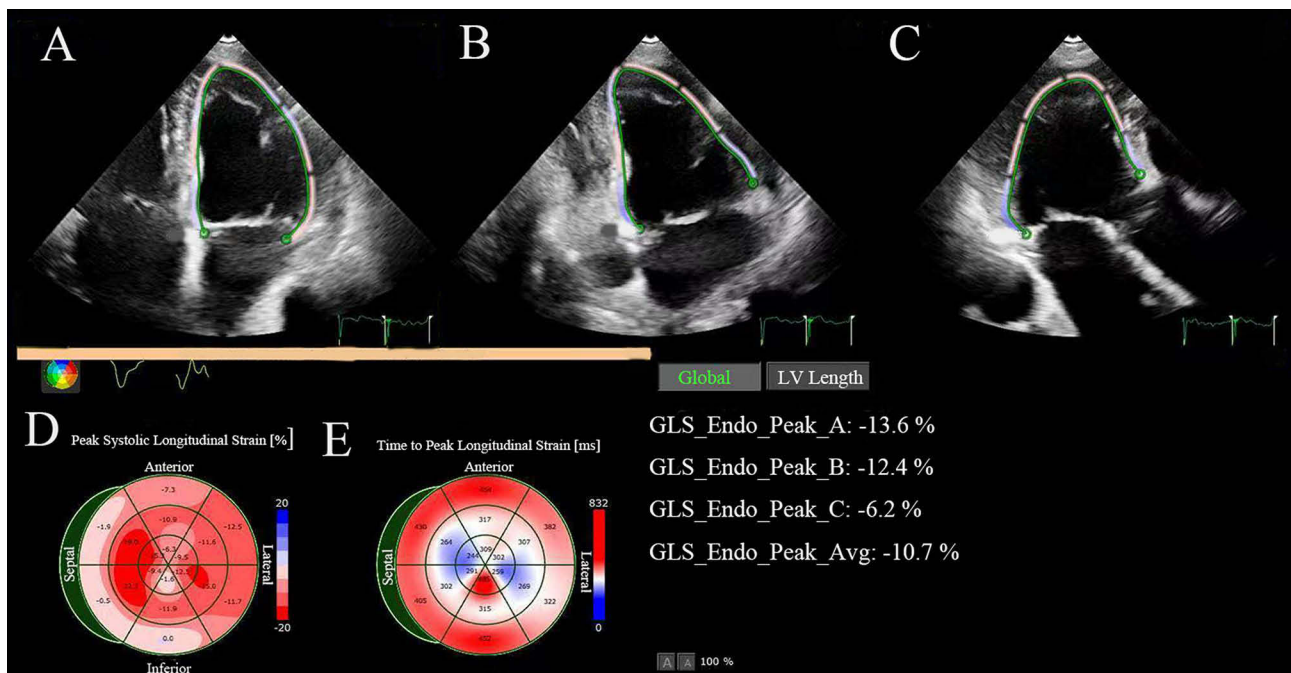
Speckle tracking echocardiography (STE) assessment of left ventricular global longitudinal strain (LVGLS). Images were acquired using a Philips EPIQ 7C ultrasound system with a S5-I transducer (frequency range: 1.7–2.0 MHz). The tracking analysis was performed offline using QLAB version 13.0. (A–C) display the apical four-chamber (A4C; A), two-chamber (A2C; B), and three-chamber (A3C; C) views, respectively, with automated endocardial border tracking for longitudinal strain analysis throughout the cardiac cycle. (D) presents a bull's-eye plot summarizing the segmental peak systolic longitudinal strain values (%), while (E) shows the corresponding time-to-peak strain for each segment. The globally reduced LVGLS of -10.7% suggests subclinical left ventricular dysfunction.
